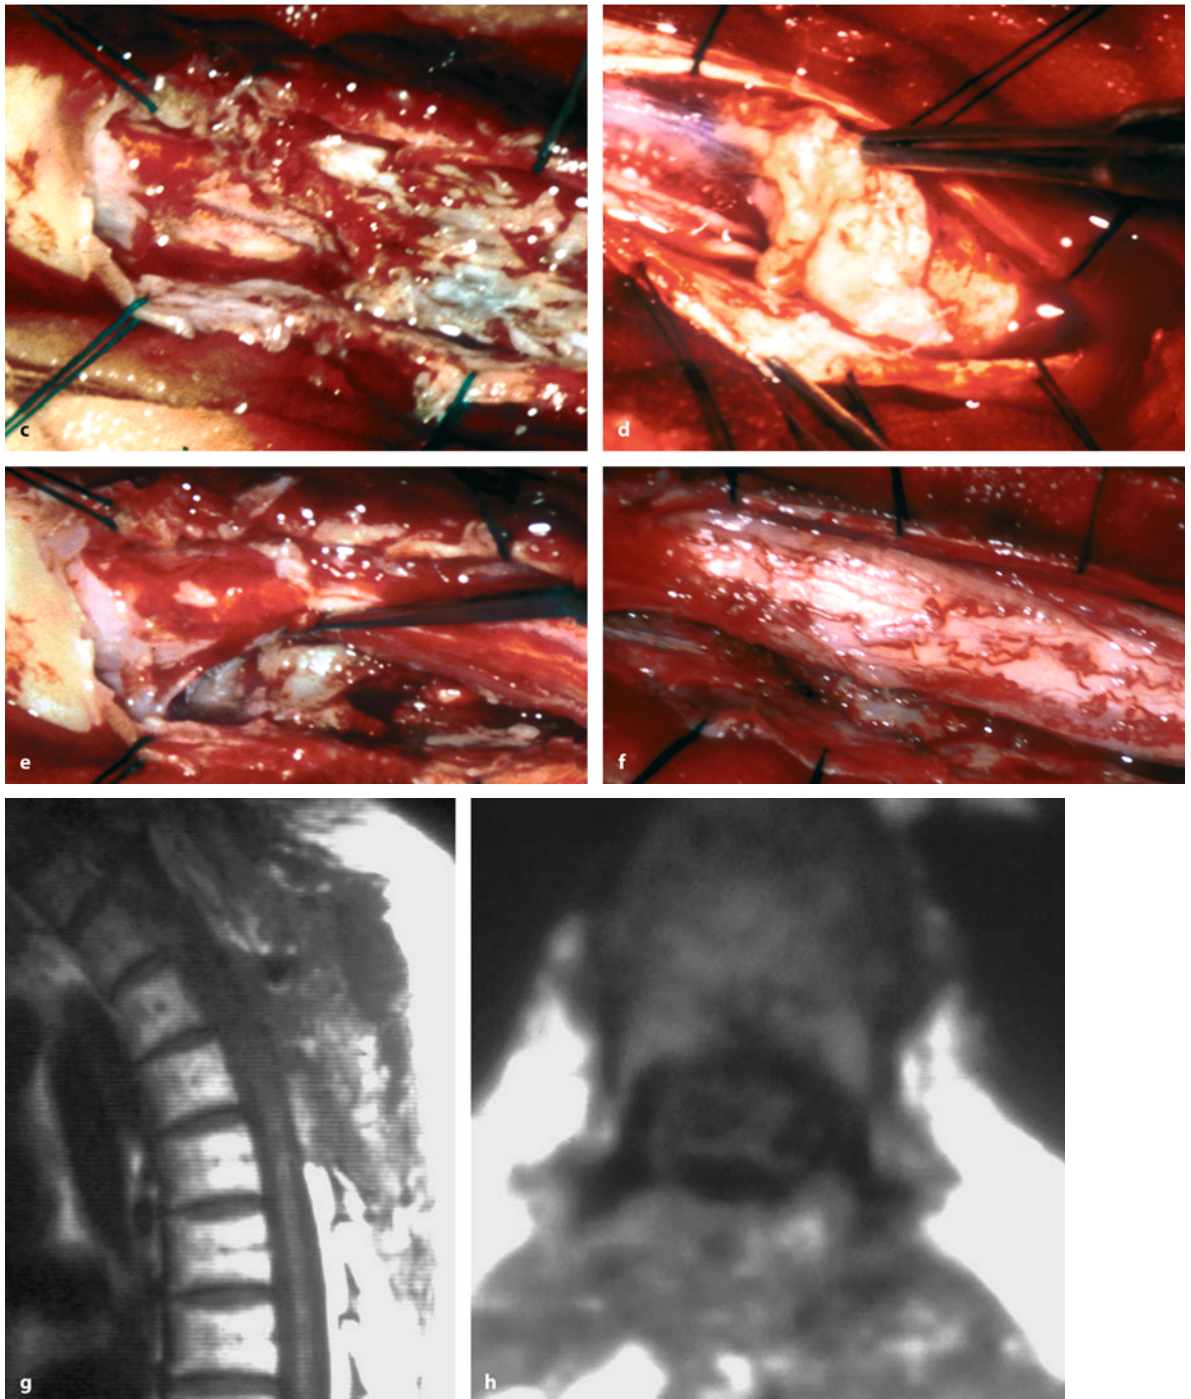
(Continued) The patient's sensory changes improved postoperatively, and has been free of a recurrence for 1 year, as demonstrated on these contrast-enhanced sagittal (h) and axial (i) MRI scans
